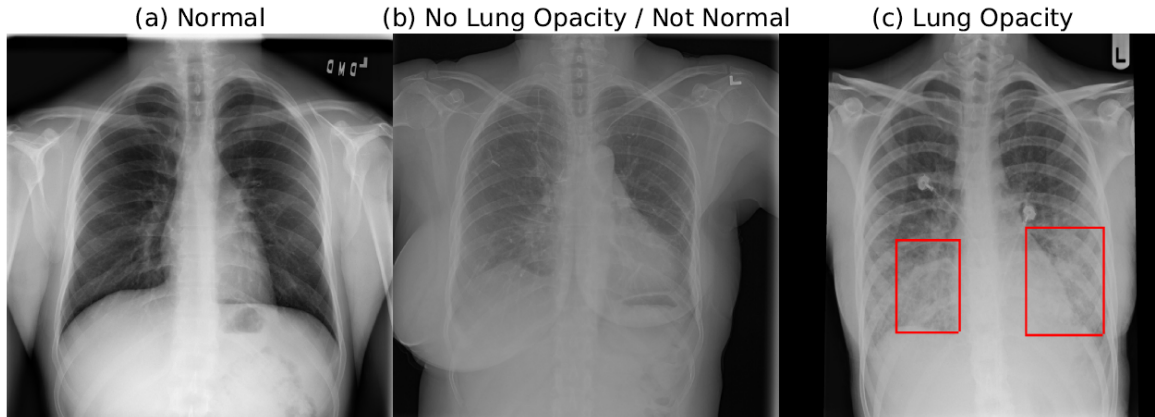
Examples of the chest X-ray images for (a) "Normal", (b) "No Lung Opacity / Not Normal", and (c) "Lung Opacity" cases. The lung opacities regions are shown on (c) with red bounding boxes.
